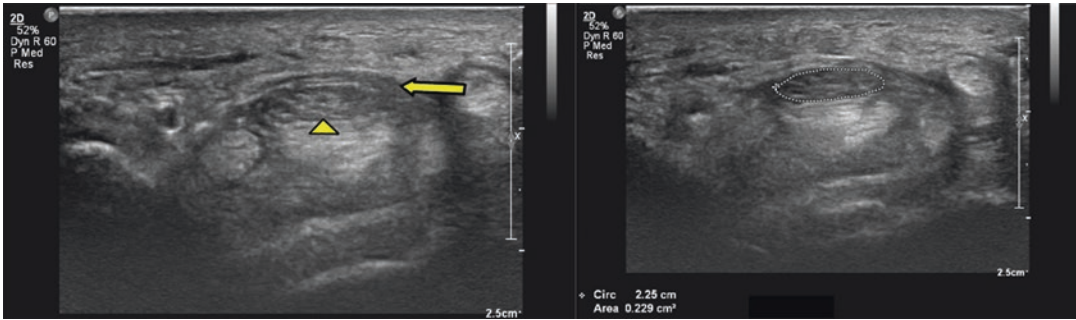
Axial ultrasound image—median nerve enlargement (*arrowhead*) and flexor retinaculum thickening and bowing at the carpal tunnel inlet. The cross-sectional area $>10 \text{ mm}^2$ is highly sensitive and specific for CTS
